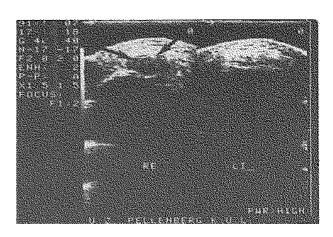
Sonography: shows intratendinous quadriceps haematoma R (arrow).
